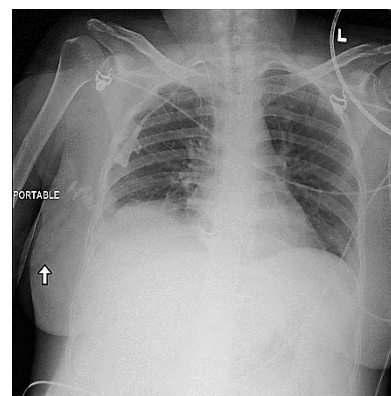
Atelectasis Chest X-ray
